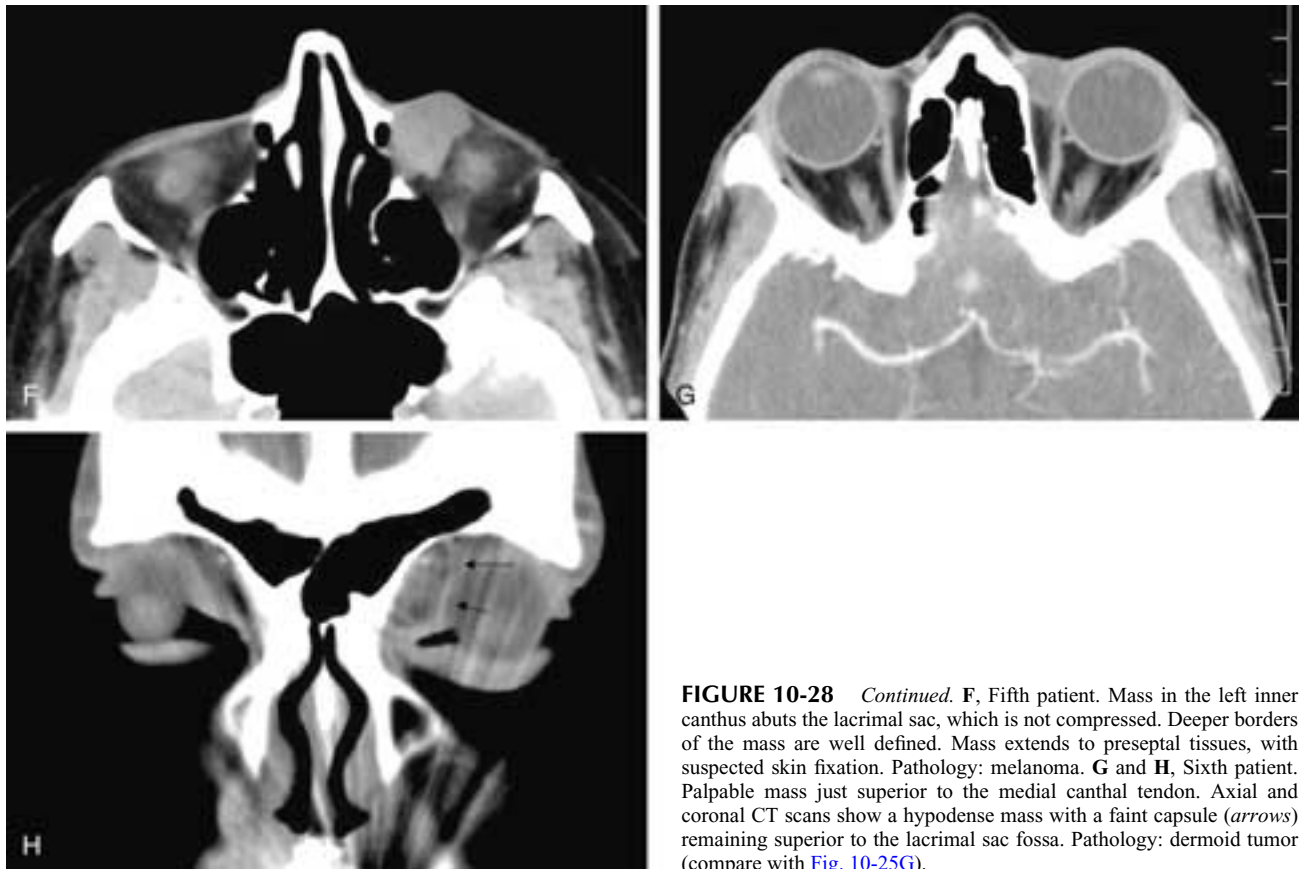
Continued.* F, Fifth patient. Mass in the left inner canthus abuts the lacrimal sac, which is not compressed. Deeper borders of the mass are well defined. Mass extends to preseptal tissues, with suspected skin fixation. Pathology: melanoma. G and H, Sixth patient. Palpable mass just superior to the medial canthal tendon. Axial and coronal CT scans show a hypodense mass with a faint capsule (*arrows*) remaining superior to the lacrimal sac fossa. Pathology: dermoid tumor (compare with Fig. 10-25G).
